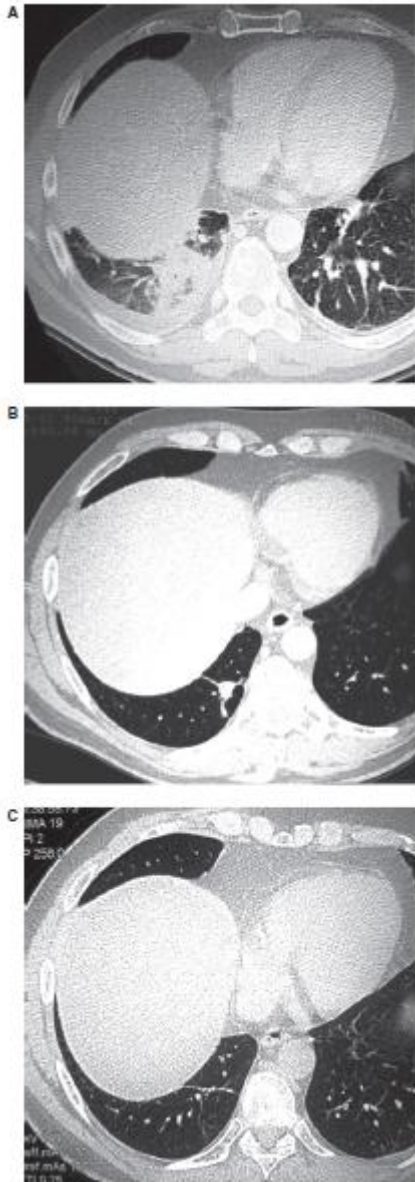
High-resolution computed tomography scans of the lungs: nodular opacity with halo sign in the right lung with plural effusion at 1 month post transplant (A); disappearance of the ground-glass halo sign and major reduction in the nodular opacity at 2 months post transplant (B); complete resolution of the lung infiltrate at 12 months post transplant (C).
